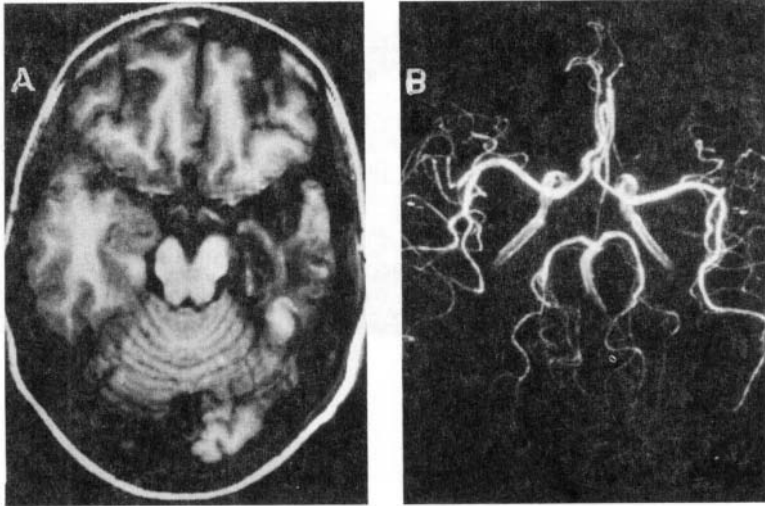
Atrophy following herpes simplex encephalitis. T1-weighted axial image (a) shows evidence of atrophy of left temporal lobe. MR angiogram (b) shows no obvious abnormality.
